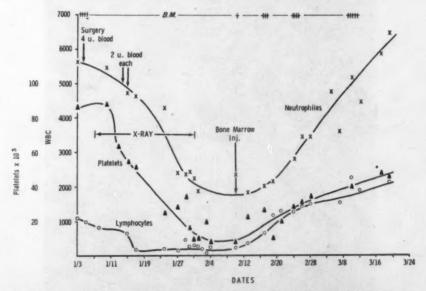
Case 1. Granulocyte, lymphocyte, platelet and bone marrow (BM) response to second course of x-radiation to five 10 by 20 cm. ports obliquely directed to the lumbodorsal spine (estimated additional tissue dose, 2,000 r), Jan. to March, 1958. X-ray factors were essentially the same as for figure 1.
